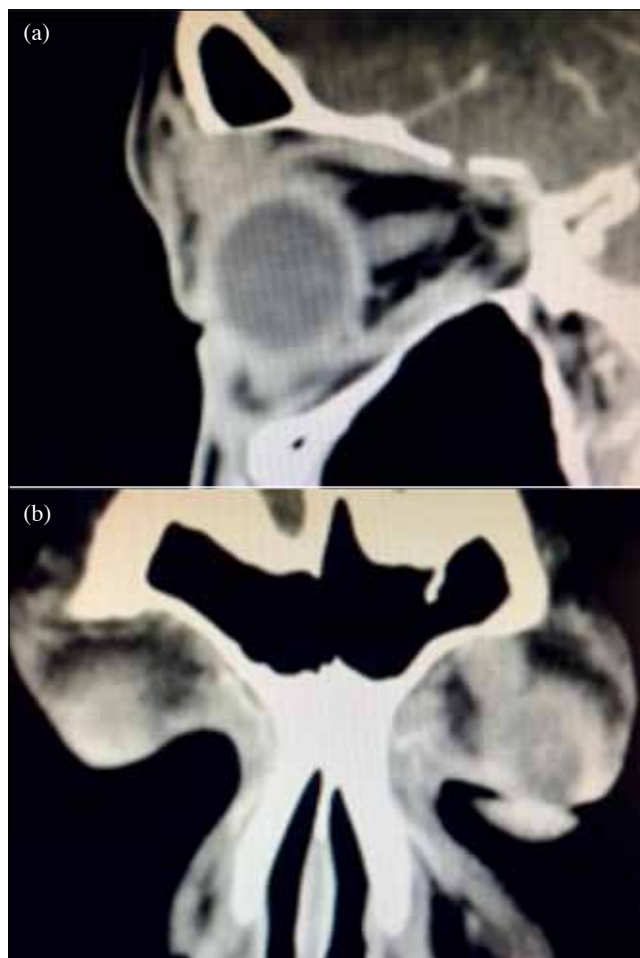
(a) Sagittal and (b) coronal views of contrast-enhanced computed tomography of the left orbit showing a moderately enhancing ovoid solid mass at the superomedial aspect of the extraconal left orbit. There are no aggressive features (bony destruction or invasion to surrounding structures), fluid, macroscopic fat component, or evidence of calcification. The left globe, lacrimal gland, and extraocular muscles are normal.
